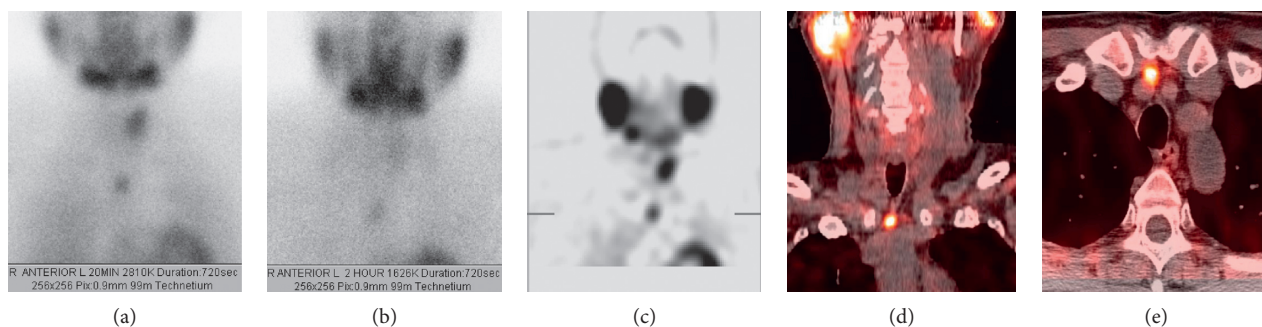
Ectopic mediastinal adenoma. A 56-year-old female presents with persistent hyperparathyroidism after prior four-gland parathyroidectomy and right thyroid lobectomy. Planar sestamibi scintigraphy at 20 minutes (a) and two hours (b) and coronal single-photon emission computed tomography (SPECT) (c) show a hypermetabolic mediastinal gland. Coronal (d) and axial (e) hybrid SPECT and computed tomography (SPECT/CT) confirm an ectopic and adenomatous fifth gland in the anterior mediastinum.
